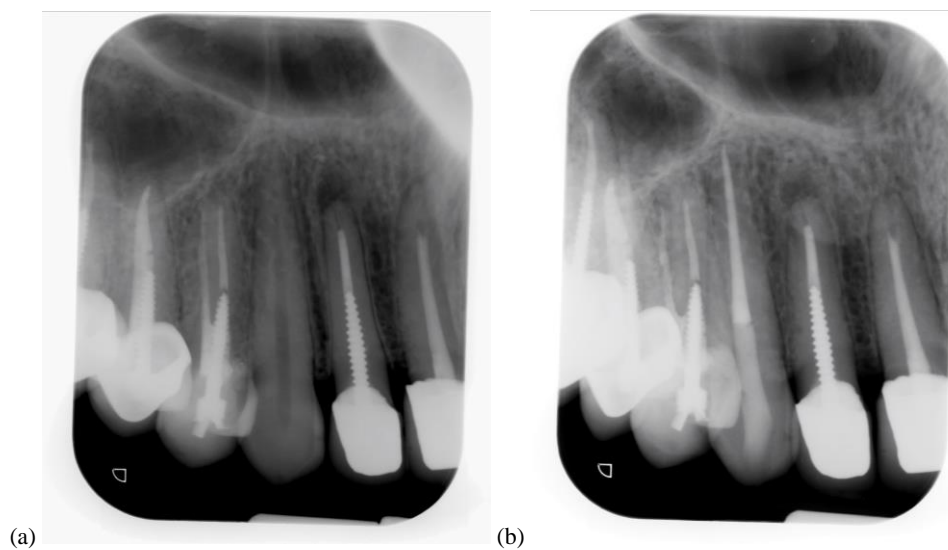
Intraoral radiographs of a tooth before (a) and after (b) root canal treatment.
